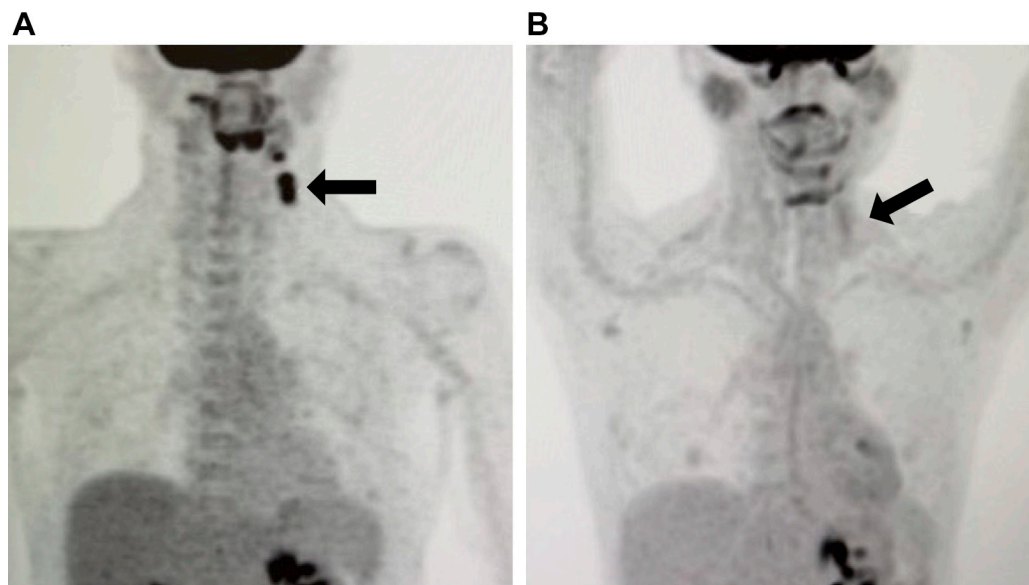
Remission of recurrent metastatic squamous-cell carcinoma of the tongue as shown by [^{18}F]fluorodeoxyglucose (FDG)- positron emission tomography (PET)/computed tomography. (A) FDG uptake by the recurrence of squamous cell carcinoma in the left submandibular region following curative-intent surgery and subsequent chemotherapy on February 25th, 2025. (B) Disappearance of FDG uptake upon PET imaging after the incorporation of a low-methionine diet and oral recombinant methioninase combined with chemotherapy on October 30th, 2025.
